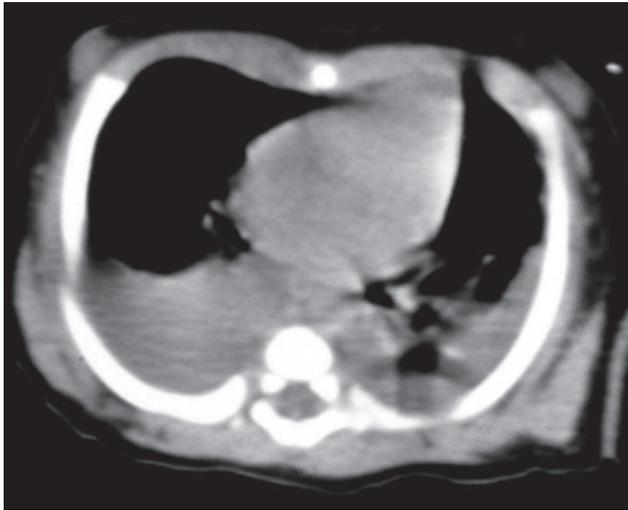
Chest CT demonstrated pleural effusion in bilateral thoracic cavities.
